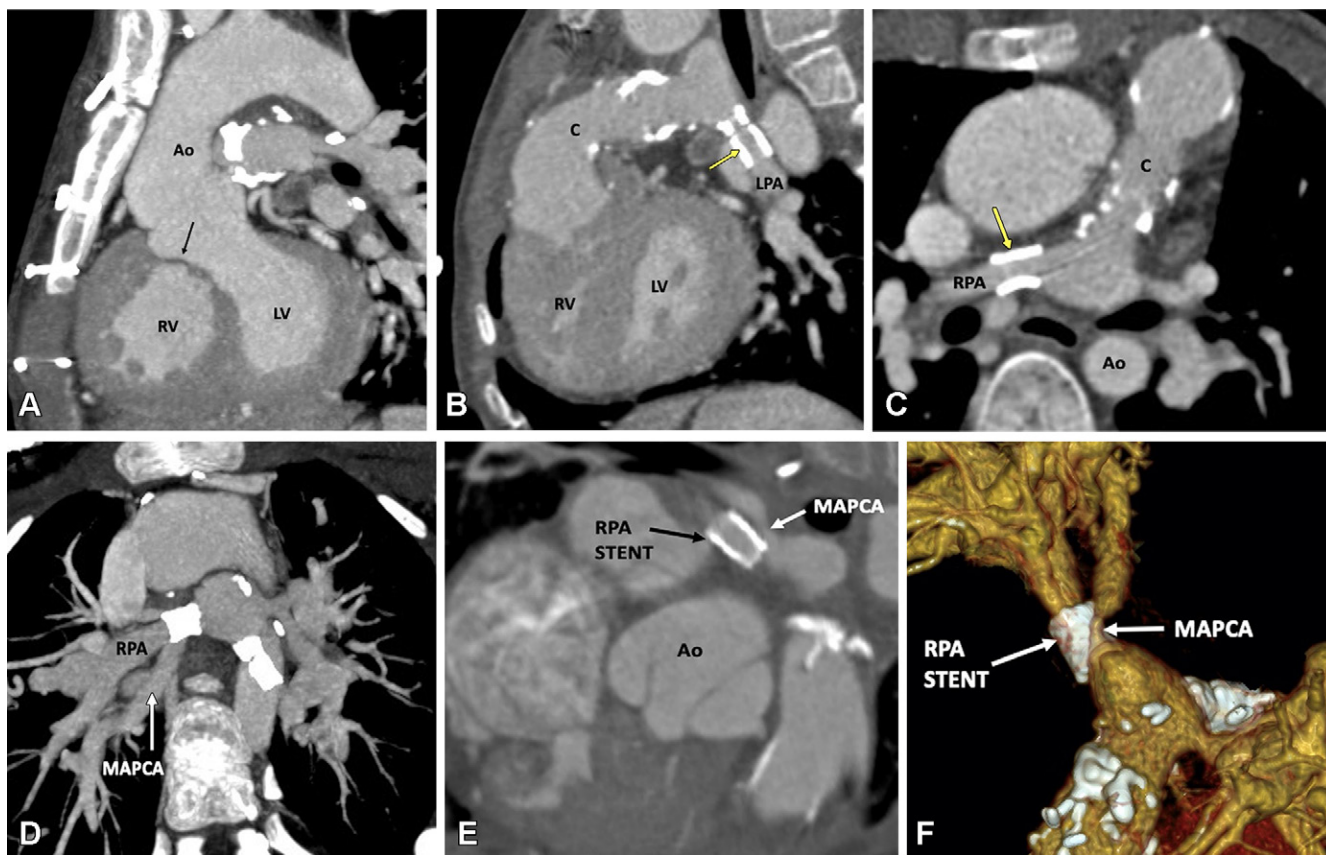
Postoperative appearance of tetralogy of Fallot with pulmonary atresia after RV-PA conduit (pulmonary homograft) repair, unifocalization of the MAPCAs, and angioplasty of the bilateral pulmonary arteries in a 14-year-old boy. (A) Sagittal oblique maximum intensity projection (MIP) CT image shows a VSD patch (black arrow). (B) Sagittal oblique and (C) axial oblique MIP CT images show RV-PA conduit with multifocal degenerative calcifications in conduit wall. Patent stents are observed in the LPA and RPA (yellow arrow). Stent placement was performed to relieve recurrent branch PA stenosis. (D) Axial oblique MIP CT image shows a stent in the osteoproximal RPA. Another good-sized vessel is observed arising from the RPA which has a unifocalized MAPCA attached to it (white arrow). (E) Sagittal oblique multiplanar reconstruction and (F) volume-rendered images show the origin of the unifocalized MAPCA (white arrow) just proximal to the RPA stent (black arrow in E, white arrow in F). Severe stenosis is noted in the osteoproximal segment of the unifocalized MAPCA. Ao = aorta, C = conduit, LPA = left PA, LV = left ventricle, MAPCA = major aortopulmonary collateral arteries, PA = pulmonary artery, RPA = right PA, RV = right ventricle, VSD = ventricular septal defect.
